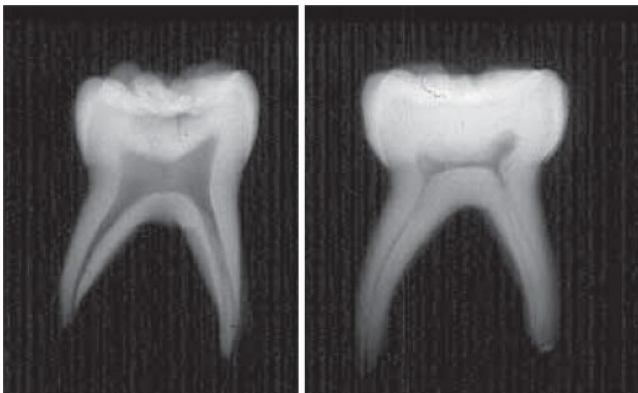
Radiographic view of primary (left) and permanent (right) molar pulp outlines.
